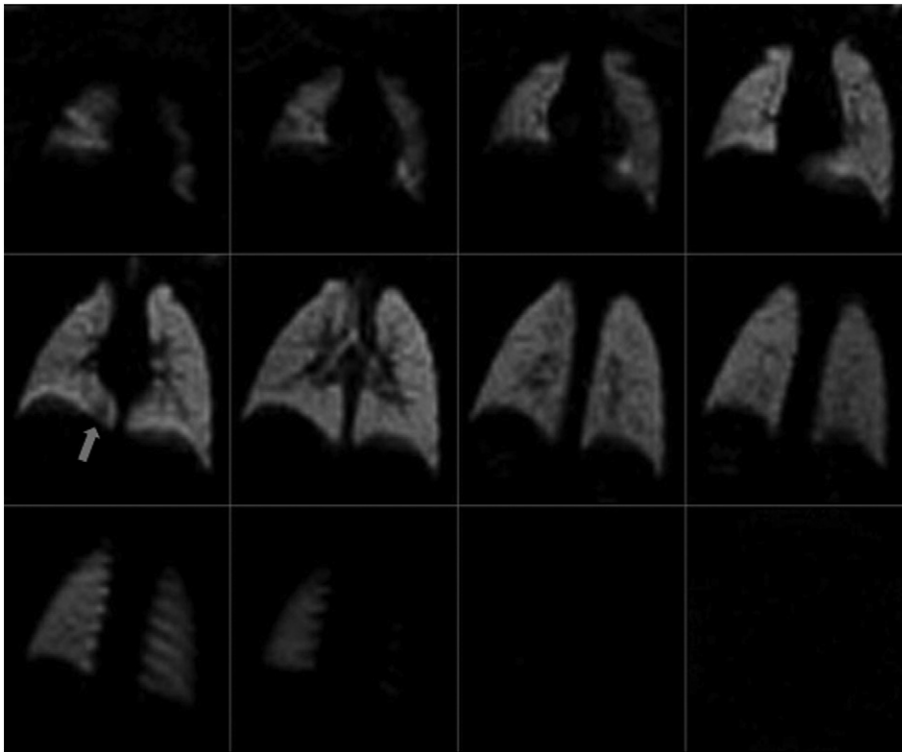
HHe coronal MR images of a 17-month-old non-sedated, unrestrained infant with CF. Homogeneous ventilation is seen throughout the lungs. A possible tiny ventilation defect is seen at the right base (arrow). No noticeable motion artifacts are noticeable.
